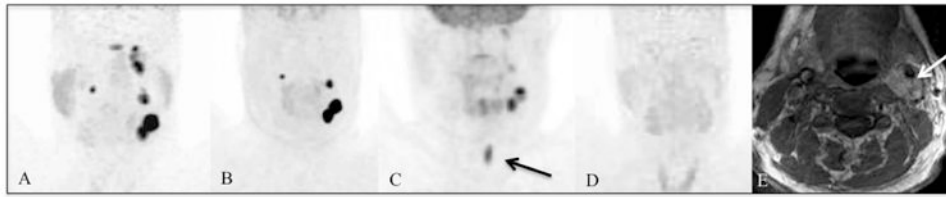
Patient 5 with *SDHD* mutation-related HNPGLs. [^{68}Ga]-DOTATATE PET/CT (A) demonstrates a lobulated finding in the CB region on the left side, additional lesions in the GV region on both sides, and in the JT region on the left side. The findings in the JT region are not visible on [^{18}F]-FDOPA PET/CT (B). [^{18}F]-FDG PET/CT (C) demonstrates the left CB and very faintly the GV and part of the JT lesions on the left side. The black arrow points to uptake in the vocal cord. [^{18}F]-FDA PET/CT (D) is completely negative. The white arrow on the MRI (E) points to the CB lesion on the left side.
